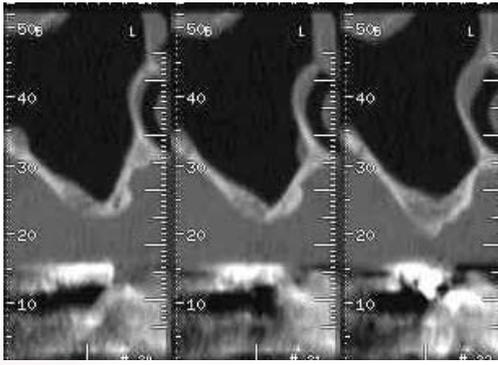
Cross-sectional view of CT scan showing 2mm high at # 16.
